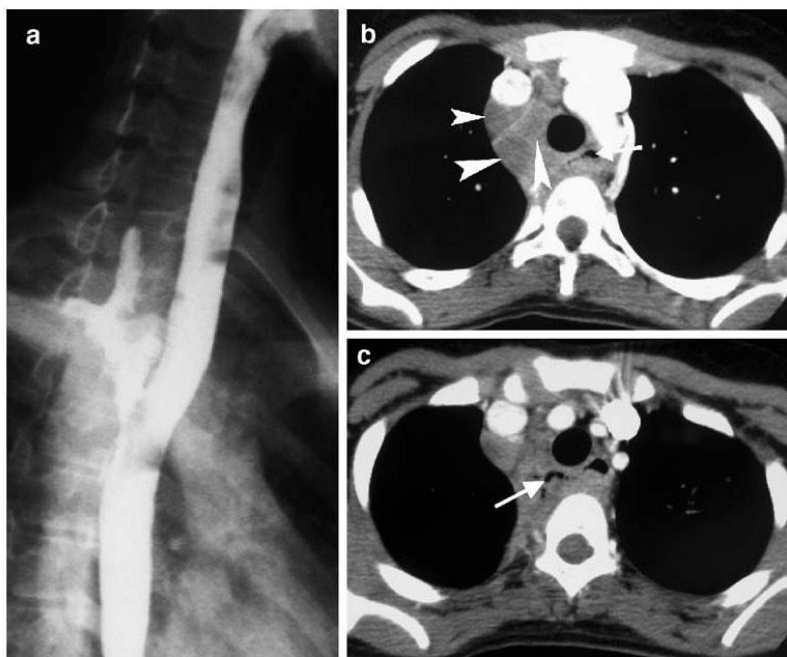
Patient 2. a Contrast swallow shows oesophageal perforation with contrast medium tracking between the oesophagus and trachea (*arrow* oesophageal contrast medium, *arrowheads* contrast medium around the trachea). b Axial contrast-enhanced chest CT demonstrates low-density mediastinal lymphadenopathy consistent with TB. This is difficult to differentiate from a ring-enhancing collection
